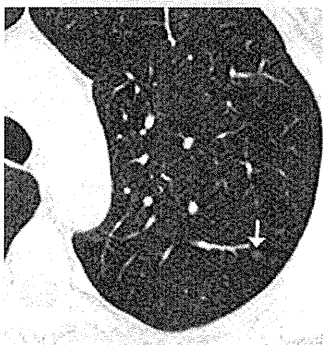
CT of preinvasive lesion (AAH or AIS). Axial 2-mm image through the left upper lobe shows a 5 mm pure ground-glass nodule (GGN), which has remained stable for 8 years (arrow). AAH and AIS can be single or multiple. AIS, adenocarcinoma in situ; CT, computed tomography.
